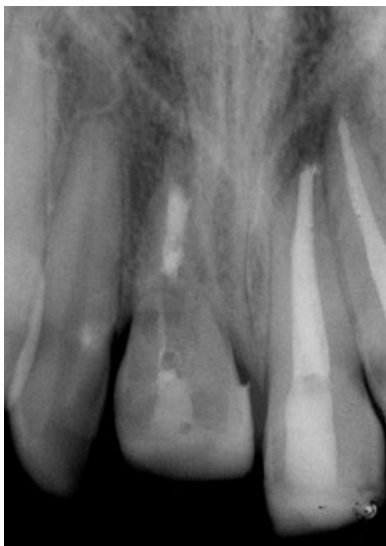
Radiograph of ankylosed maxillary right central incisor.
